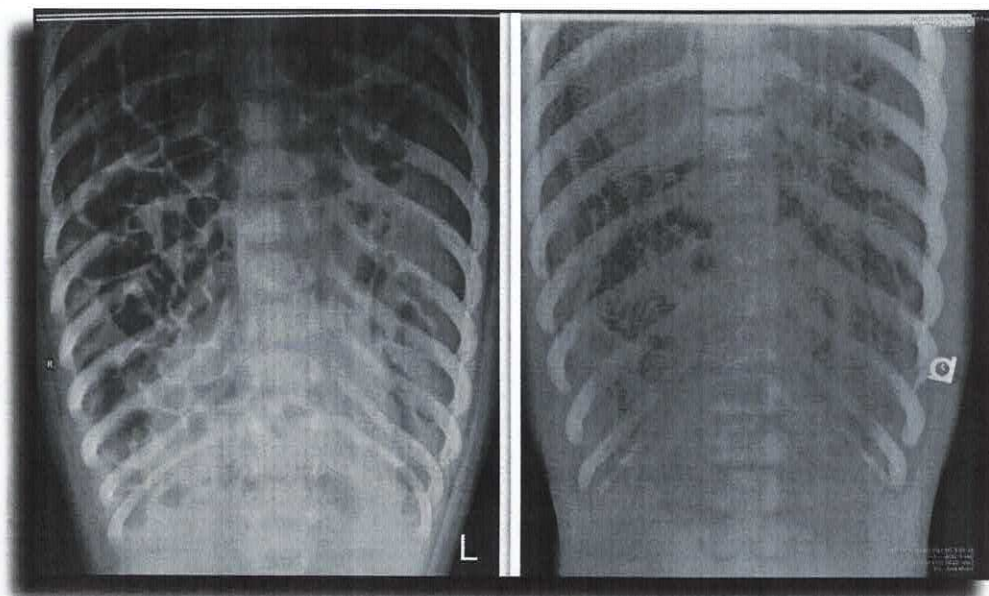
(Left) Dorsoventral radiograph of a FL manatee calf demonstrating large amount of gastrointestinal gas. (Right) Dorsoventral radiograph of a FL manatee calf with pneumatosis intestinalis. Note intramural gas within the wall of the gastrointestinal tract in multiple locations. (Courtesy of SeaWorld Parks & Entertainment, Inc.)
